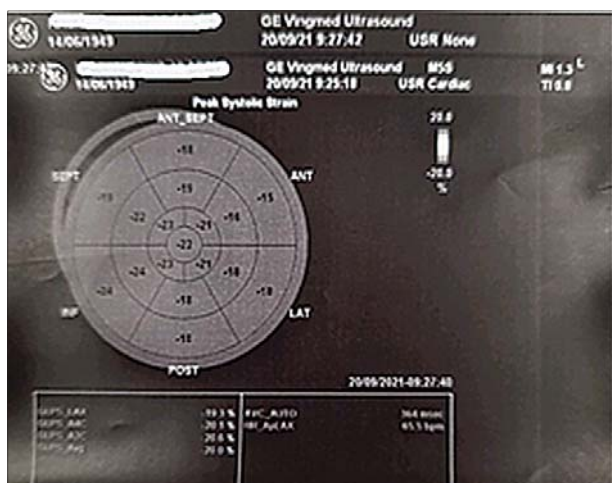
Stress echocardiography before pharmacology test
